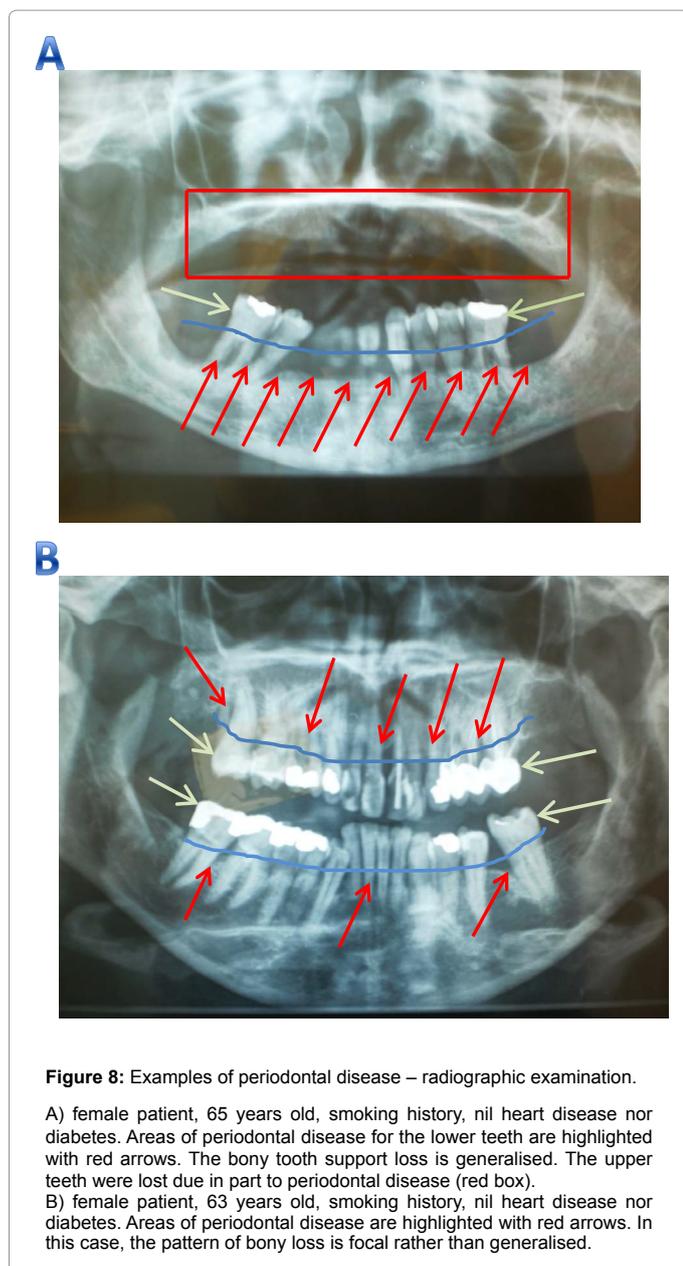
Examples of periodontal disease – radiographic examination.
